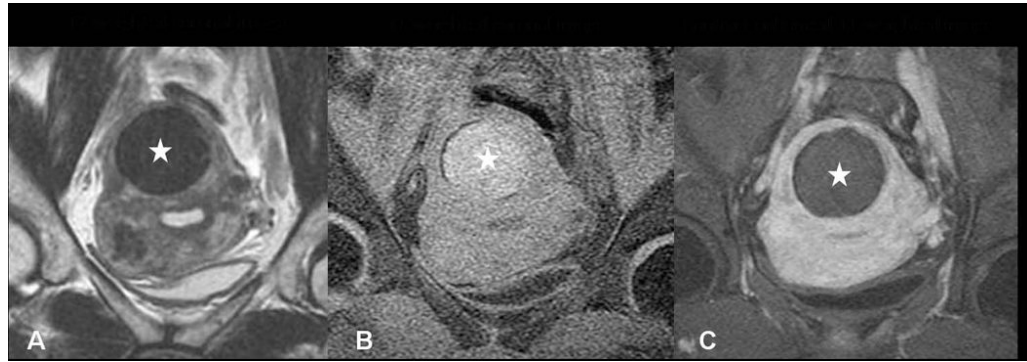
Degenerated fibroid, pretreatment screening MRI. The fibroid (stars in A, B and C) shows low signal intensity on T2 weighted imaging (A) and high intensity on T1 weighted imaging (B). (C) After IV Gadolinium contrast administration, it shows no enhancement.
